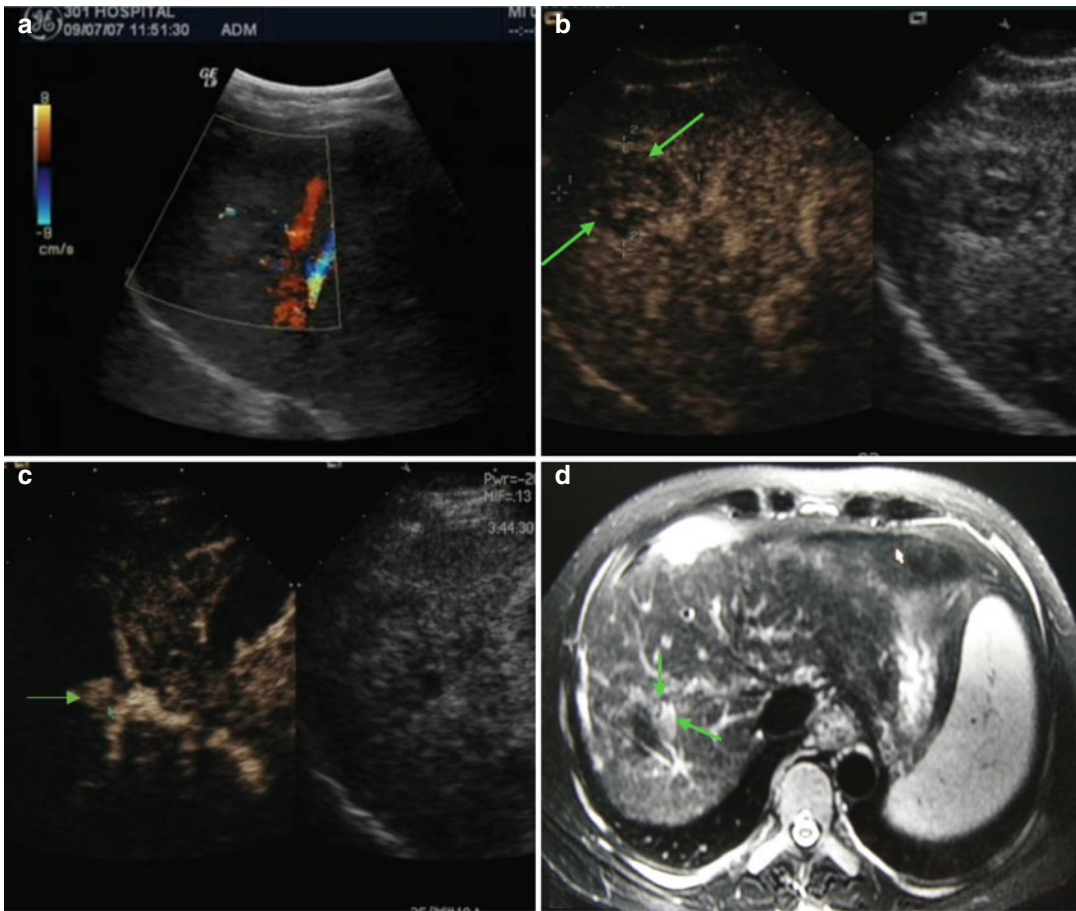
The patient is male, 73 years old, diagnosed as with hepatocellular carcinoma (HCC) (3.3×2.2 cm) for 1 month, underwent the contrast-enhanced ultrasound (CEUS) and contrast-enhanced magnetic resonance (CEMR) before the operation. After the necessary examination, the patient underwent microwave ablation (MA). Both the CEUS and the CEMR showed recurrence of the lesion after 2 months, and the patient was treated by microwave
